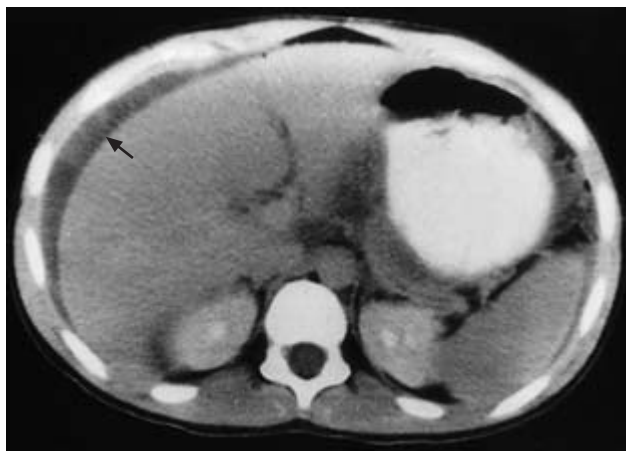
CT in chlamydial peri-hepatitis shows 'violin string' adhesions between liver and anterior abdominal wall (arrowed) and ascites.
